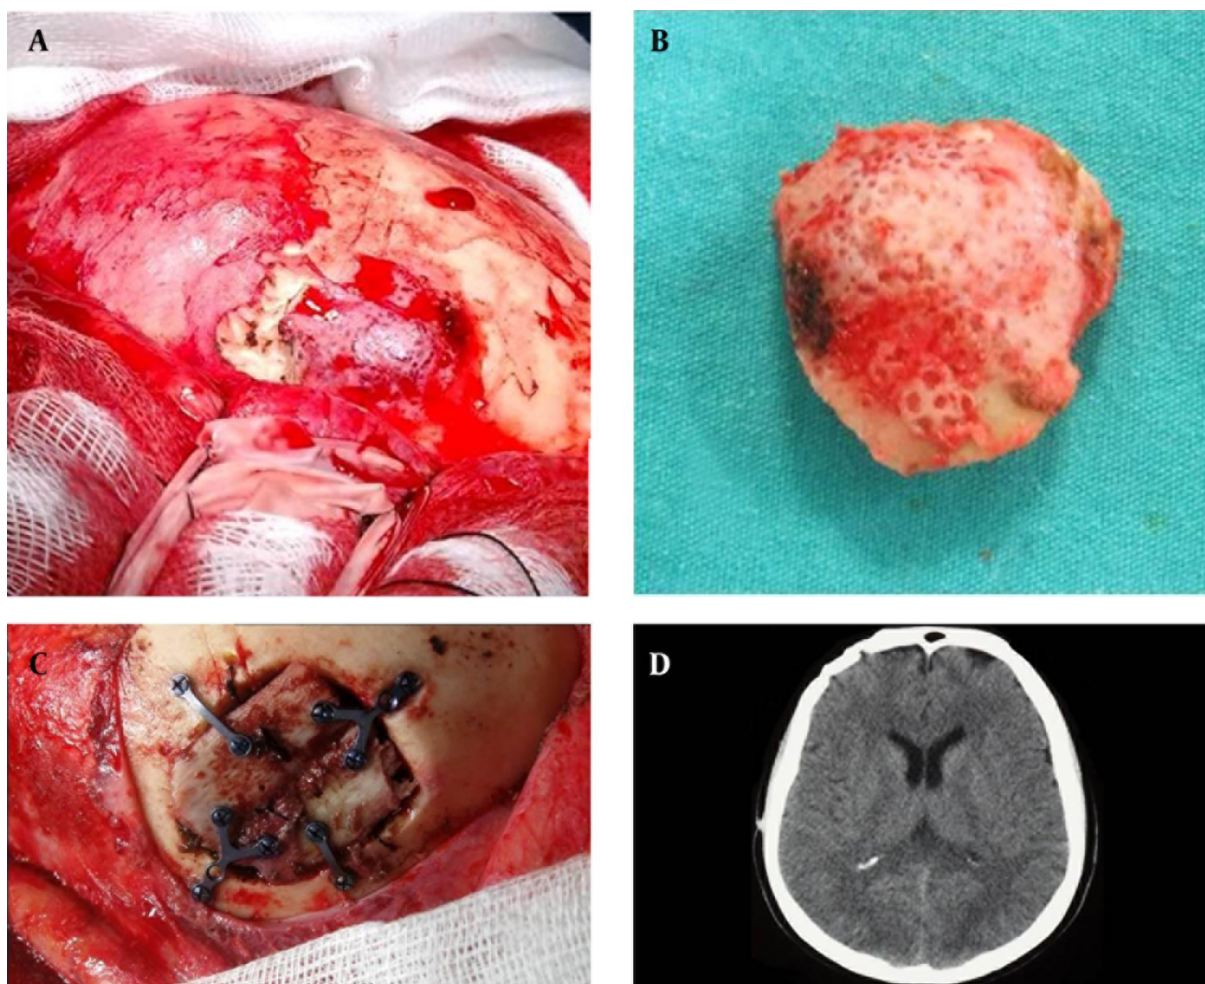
A, the image of the mass over the frontal bone; B, the image of the lesion after craniotomy, C, after the split costa had been applied on the defect to cover it by means of mini plaques, D, the CT image of the cerebrum showing that the defect in the cranium had fully fused with the costa at the end of the first year of the case.
